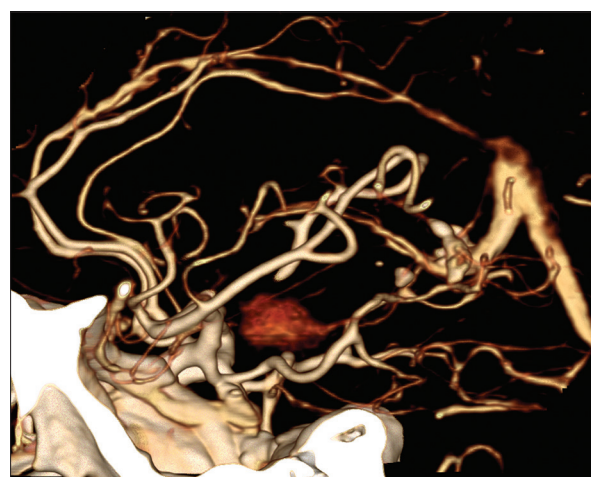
Three-dimensional reconstruction of CT angiography. Lateral projection demonstrates contrast uptake of hypervascular lesion with no discrete arterial connection. The anterior choroidal artery is not visualized.
